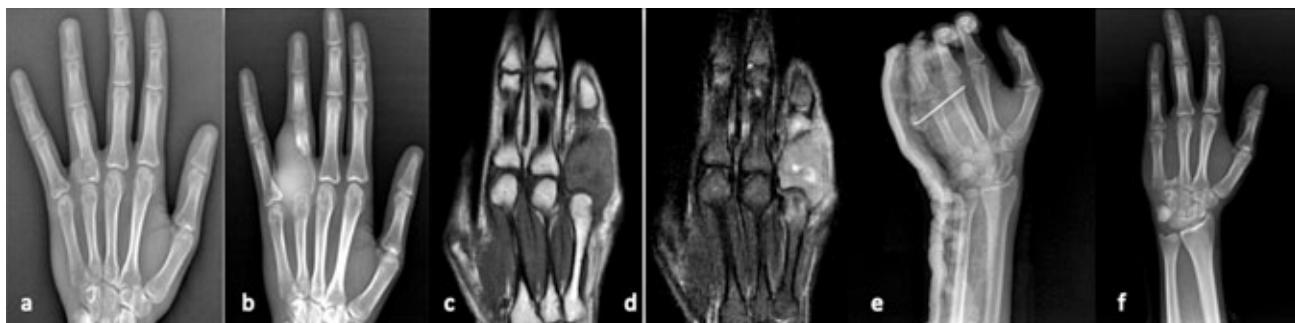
X-ray and MRI views of the hand in Case 1: a – AP roentgenography of the hand at initial admission to the hospital; b – AP roentgenography of the hand six weeks after the first admission; c – T1 and d – T2 images of the lesion on MRI; e – post-operative AP roentgenography of the hand; f – AP roentgenography of the hand two months after surgery.
